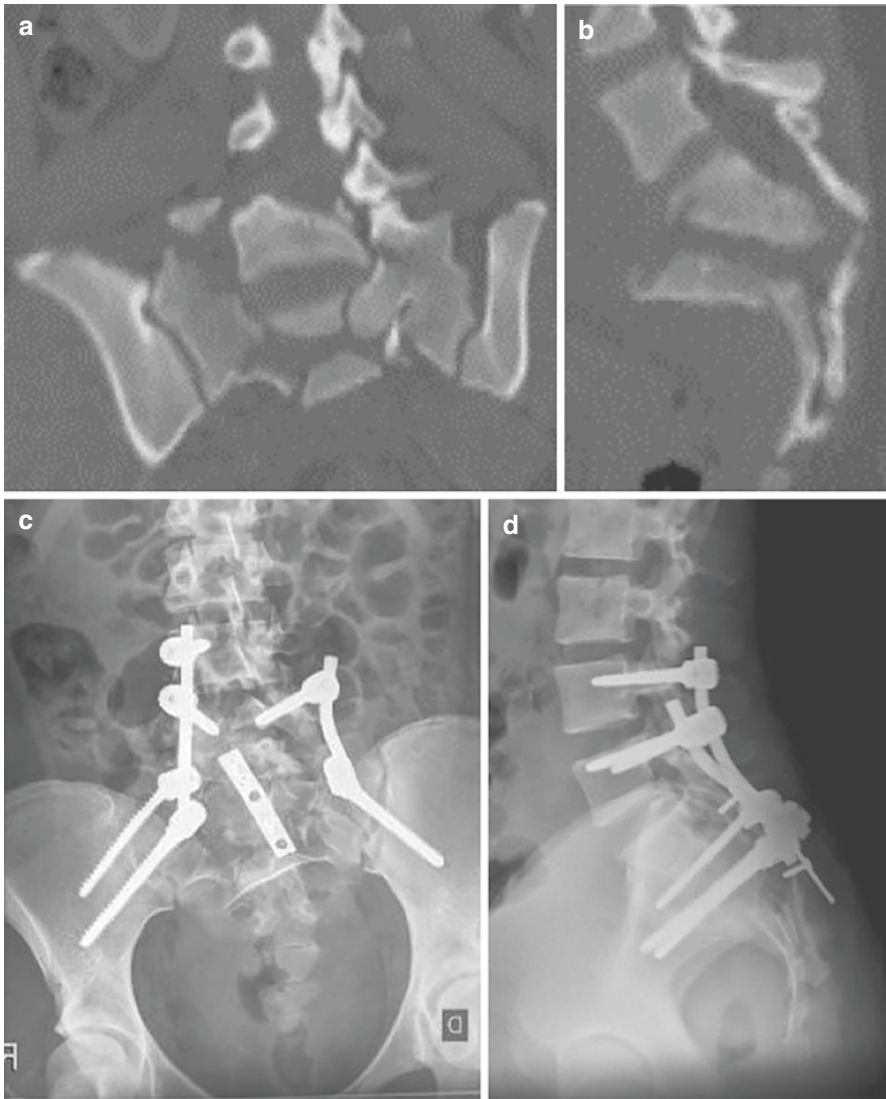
Type C3 injury; (a, b) CT scan showing displacement and instability; (c, d) surgical treatment with spinopelvic bilateral fixation and additional posterior plate
